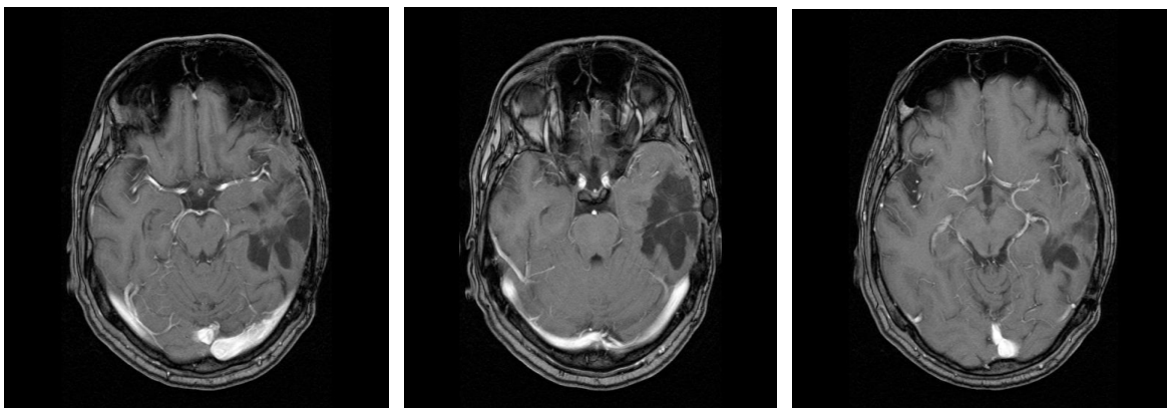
/b. Post treatment, imaging with MRI-T1 16.06.2005
